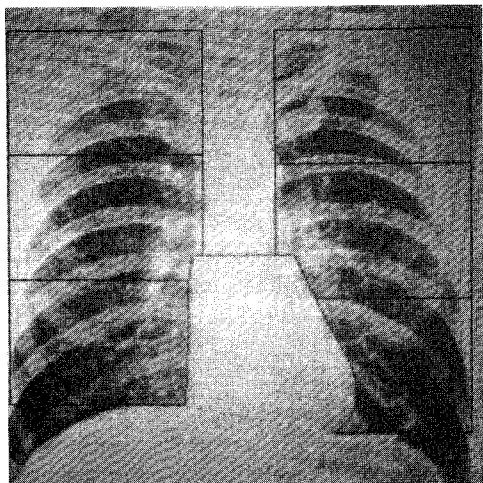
Chest radiograph with superimposed computer-calculated cardiac outline and lung zones.
